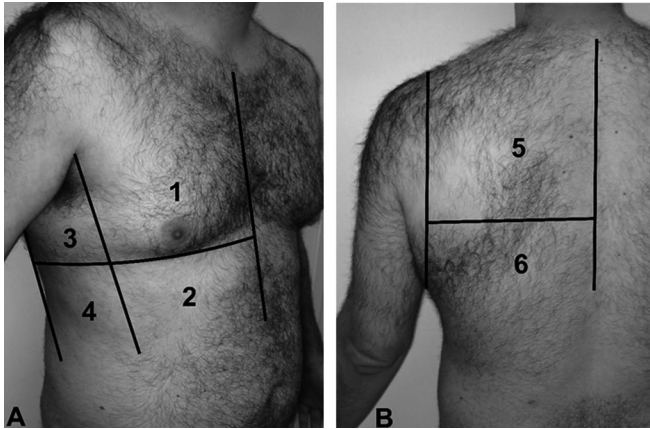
Lung ultrasound score.
